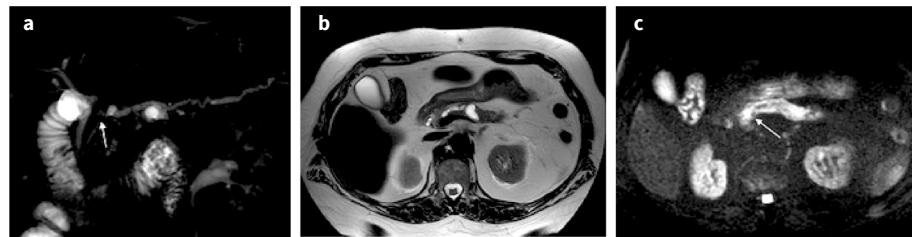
Pancreatic duct stricture. An MRCP image reveals a focal pancreatic duct stricture (arrow) (a) without any measurable mass in axial T2W image (b) but with focal restriction in DWI (arrow) (c). EUS-guided fine needle aspiration confirmed a pancreatic ductal adenocarcinoma of less than 2 cm. Reproduced with permission from Zamboni GA, et al. *Abdom Radiol (NY)* 2020; 45: 1410–1419 © (2020) Springer Nature Switzerland AG.
